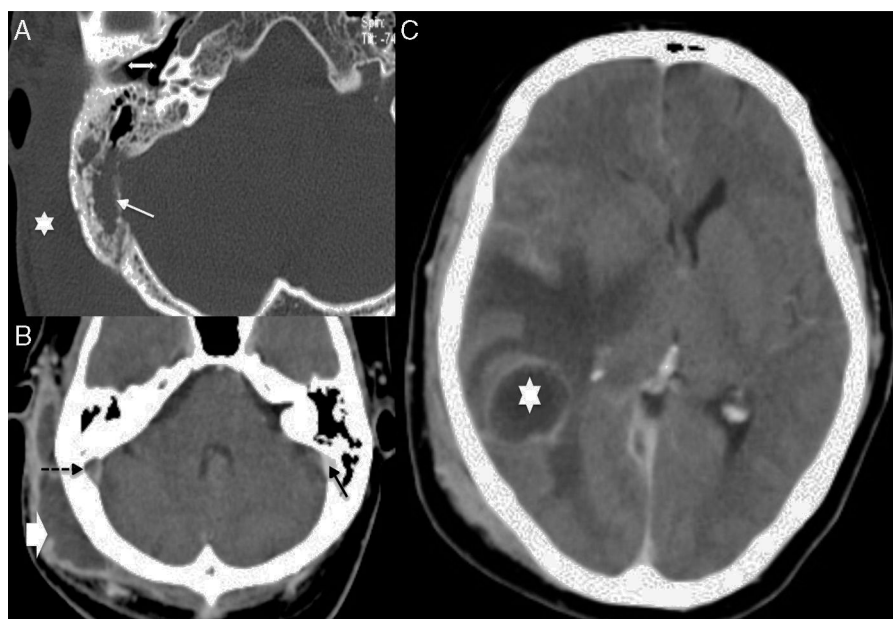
Complications of otitis. (A) Computed tomography (CT), axial section in bone window. Patient with auricular swelling (*) in A, secondary to *coalescent mastoiditis* (arrow in A). A month before he had suffered from acute otitis. At the moment of the study the eardrum was well aerated (double arrow in A). (B) CT, axial section with IV contrast. (C) CT, cranial axial section with IV contrast. This is an immunodepressed patient who presented a *subperiosteal abscess* (white arrow in (B)) and intracranial complications. The *thrombosis of the lateral sinus* was diagnosed through absence of contrast filling of the sinus (black dotted line in B) – observe comparatively with a normal filling of a healthy side (black continuous arrow in B) – and a *cerebral abscess* (white asterisk in C).
